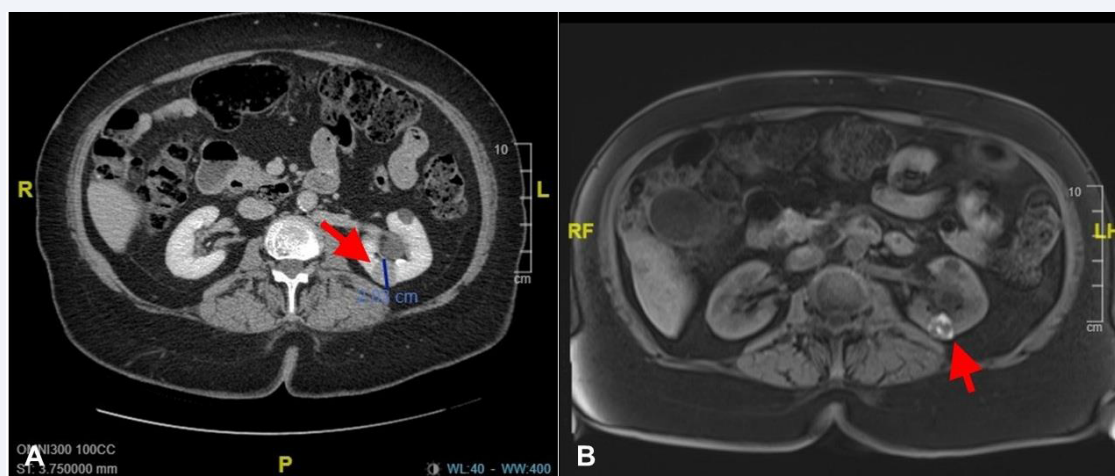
Pre-operative imaging identifies a right renal mass. (A) CT and (B) MRI (axial views) show a well-circumscribed 3.5 cm mass (arrows).
